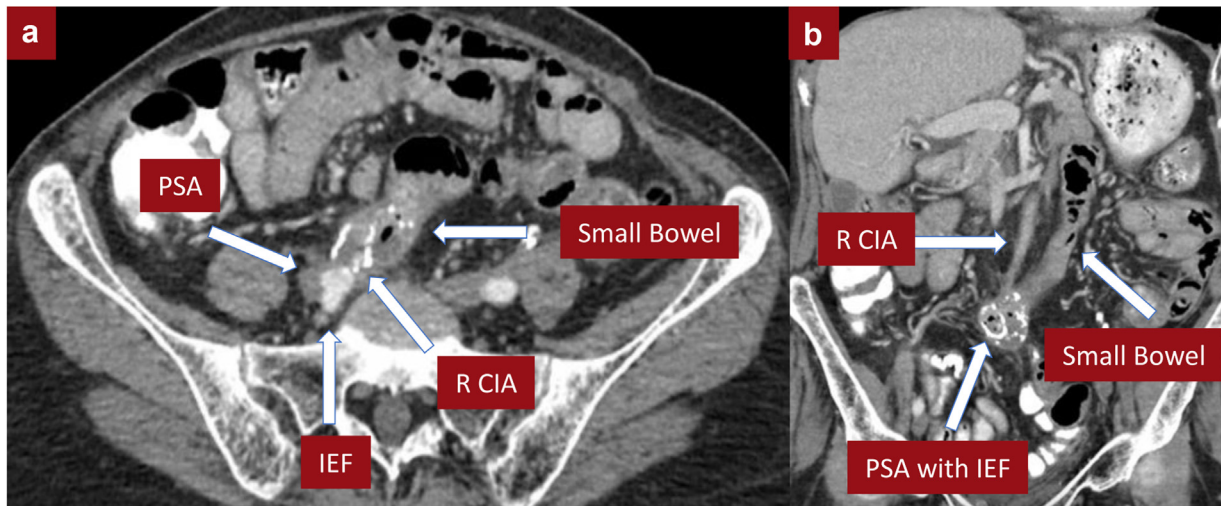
Axial (a) and coronal (b) views of computed tomography (CT) scan showing pseudoaneurysm (PSA) and iliac-enteric fistula (IEF) of the right common iliac artery (CIA) to the jejunum.
